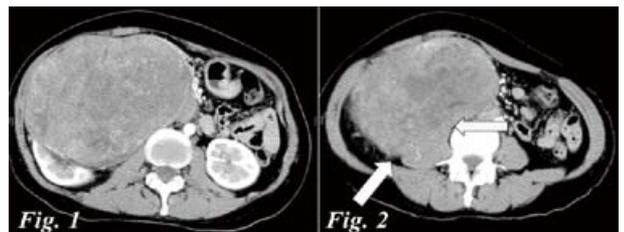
Contrast CT contained a large RT retroperitoneal mass with renal invasion.
